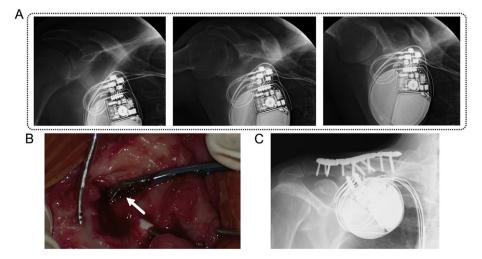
Panel A: Three representative radiographs in various right upper limb positions. The device leads seemed to be compressed by the distal right clavicle and adjacent soft tissue when the right upper limb was in the neutral position. In contrast, the device leads seemed to be less affected by the distal right clavicle when the right upper limb was elevated. Panel B: Intraoperative photograph of the inside of the device pocket. The inner wires of the right ventricular (RV) lead can be seen protruding from the outer insulation material (indicated by the white arrow). Panel C: Radiographs after surgical fixation of the right clavicle using a fixation plate.
